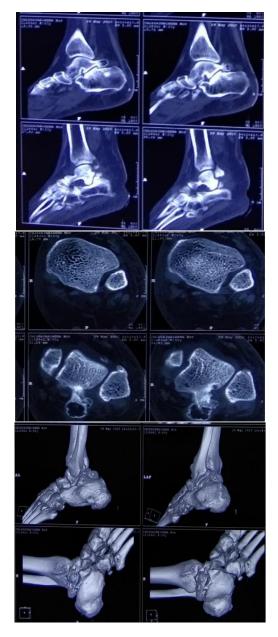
Pre-operative CT images showing the position and size of os trigonum.
